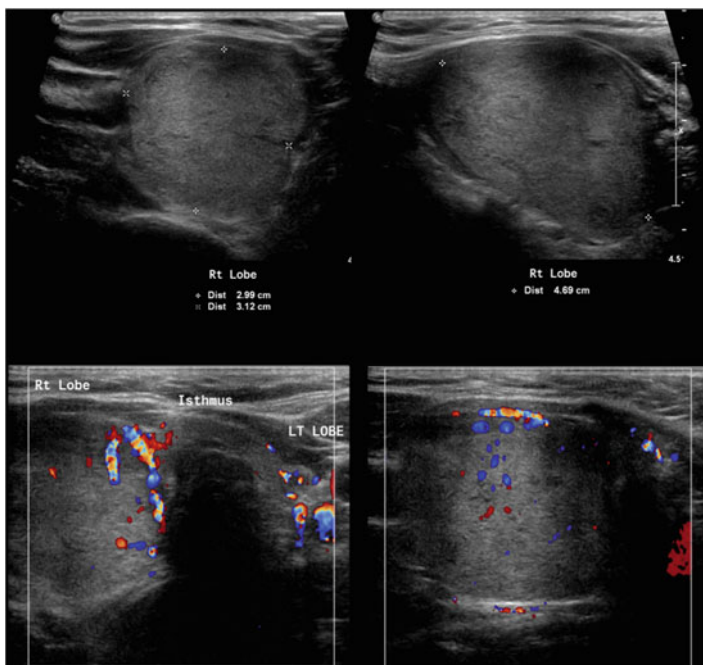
Follicular adenoma. Imaging features of thyroid neoplasms are not specific. The most common thyroid neoplasm in children is benign follicular adenoma, which may range from completely solid to mostly cystic. Here, grayscale and color Doppler US images show a large, well-defined mass (*calipers*) in the right lobe of the thyroid of a 12-year-old boy with follicular adenoma.
